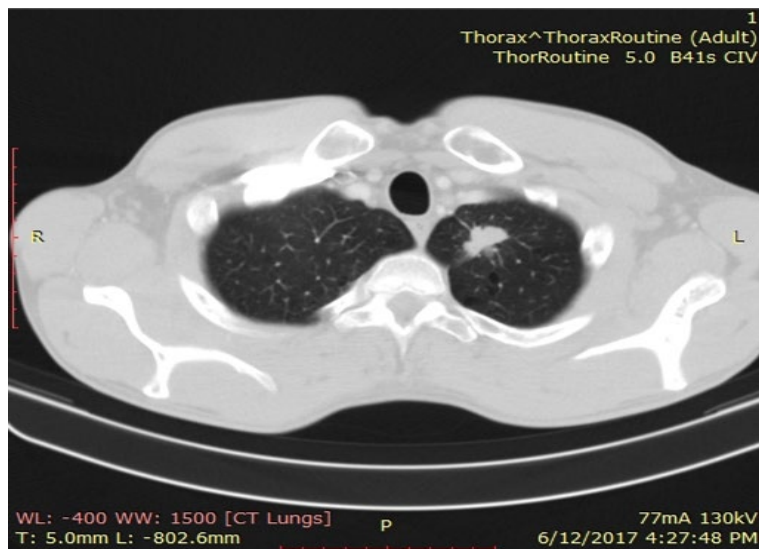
CT scan: a 25 mm nodule in the LUL, with spicules towards the mediastinal pleura
